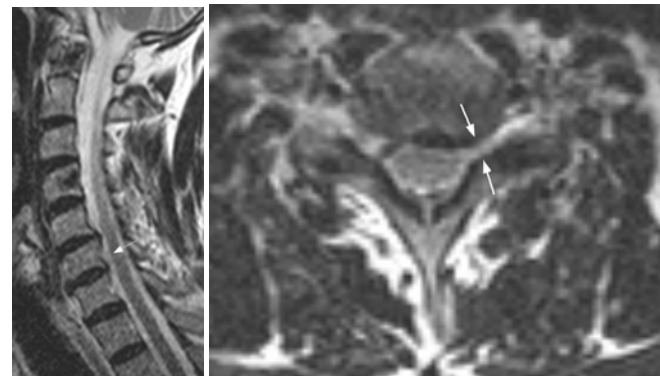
Left: Follow up T2-weighted sagittal image shows complete resorption of the sequestered disc (arrow). Right: Follow up T2-weighted axial image after 2 years demonstrates the left paracentral protrusion at the C6-7 level causing narrowing of subarachnoid space and ipsilateral neural foramen (arrow). No compression on spinal cord is observed.
